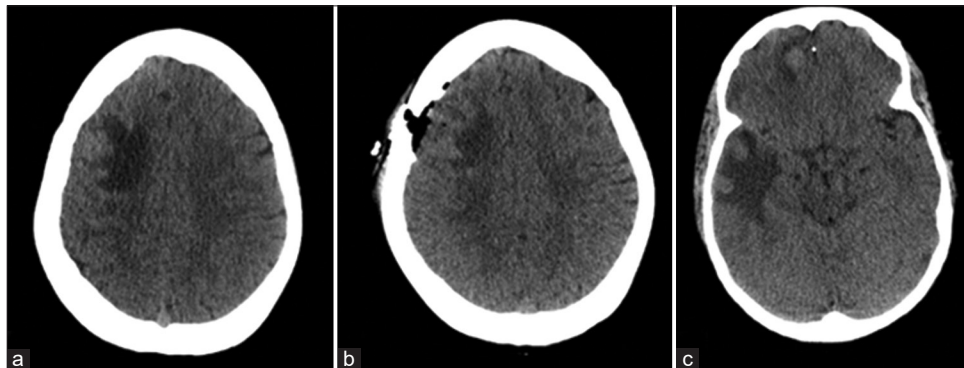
Brain axial computed tomography shows (a and b) multiple supratentorial enhancing lesions associated with edema causing effacement of adjacent sulci. (c) The largest lesion in the right parietal lobe 2.1 × 1.8 × 1.5 cm.
